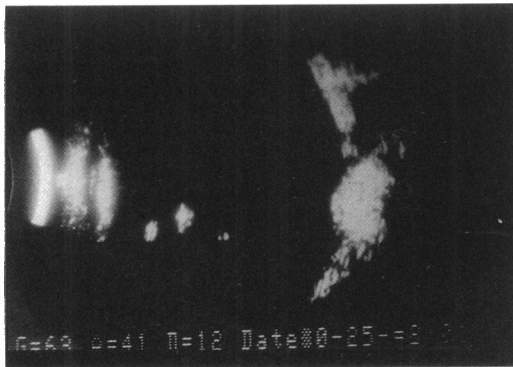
B scan ultrasonography 4½ years after the operation. Note the characteristic picture of the silastic sponge as well as the height of the chorioretinal indentation produced by the explant at the posterior pole. The location of the sponge seems to provide a barrier between the optic nerve pit and the macula.
